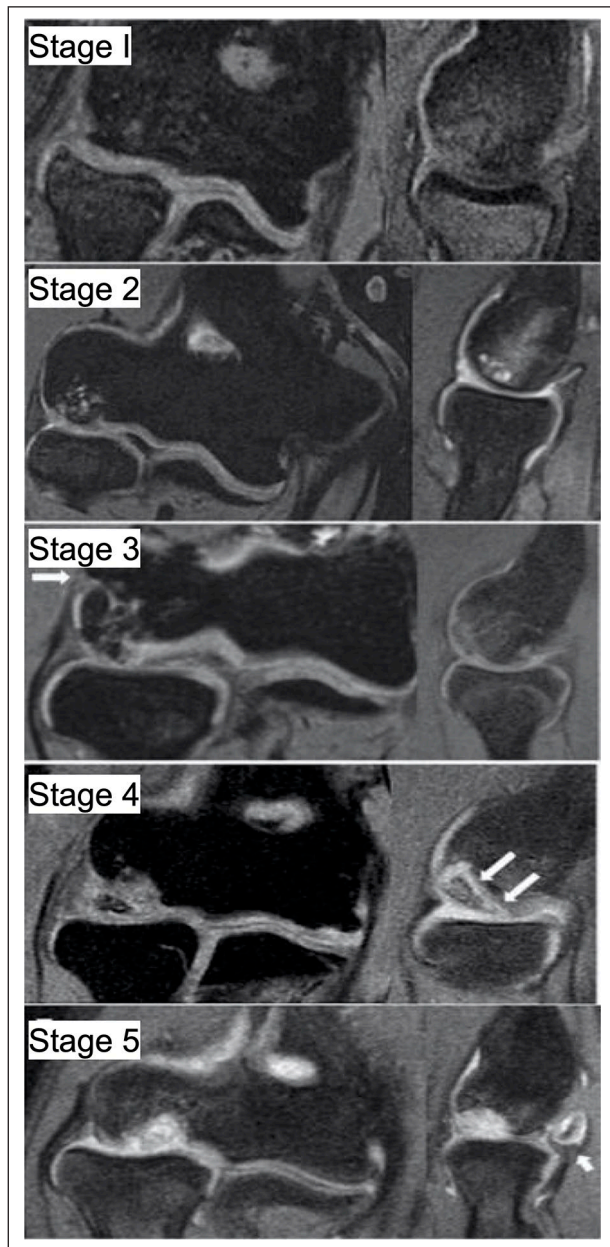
MRI staging of capitellar osteochondritis dissecans. Source: Adapted with permission from Itsubo et al.⁵⁹
